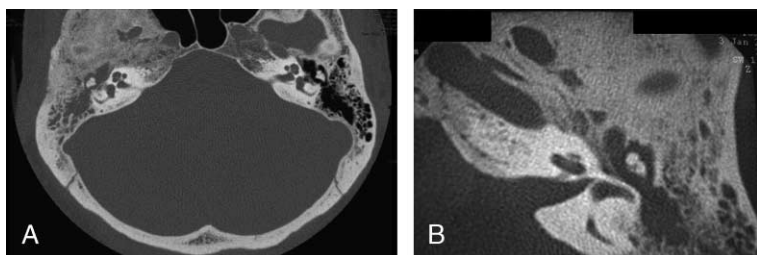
Axial CT scans showing the typical aspects of a right temporal *en plaque* meningioma in Case 2 (A) and a left temporal *en plaque* meningioma in Case 6 (B).
